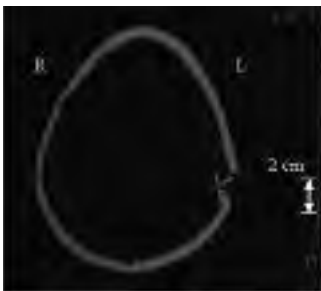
CT Image Showing Left Skull Fracture
